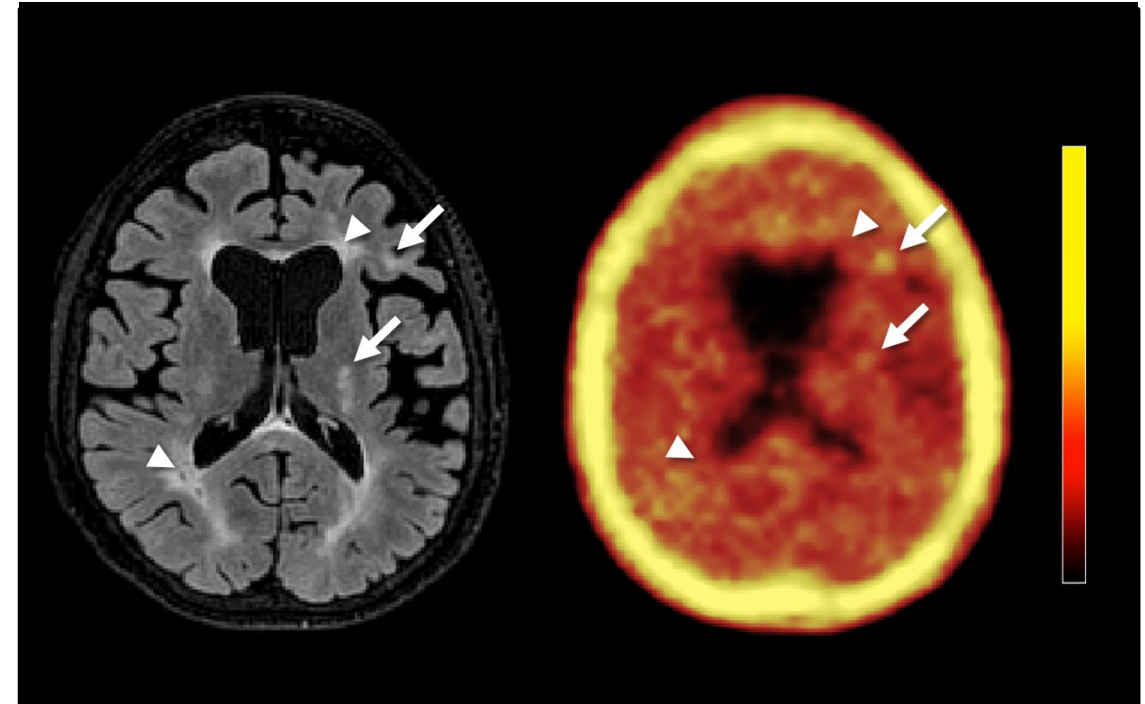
Baseline MRI T2-FLAIR image (left) and TSPO PBR06 PET SUV map (right) for a representative subject (50-year-old female with active SPMS). The PET tracer map reveals heterogeneity in lesion microglial concentration in lesions that appear otherwise similar on T2-FLAIR MRI. Some lesions (arrows) show substantial TSPO activity, while others (arrowheads) do not.
